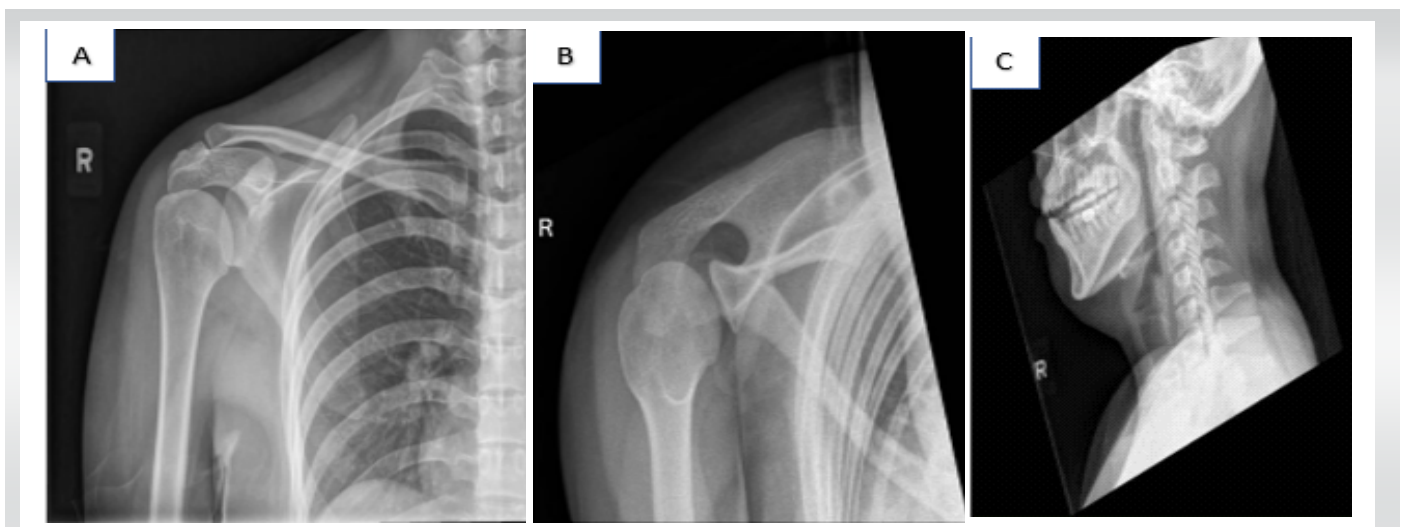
(A and B) The anterior-posterior (AP) and axillary views of the right shoulder with the humeral head are enlocated, nil fractures seen. (C) Lateral cervical spine radiograph with some mild loss of cervical lordosis and spondylotic changes at C5/C6.
